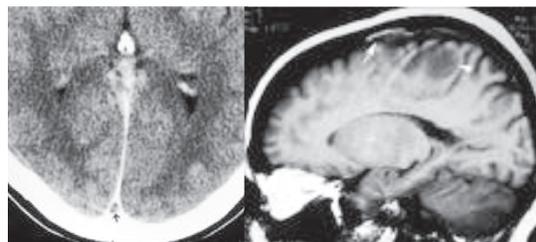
MRI shows thrombosis of superior sagittal sinus
